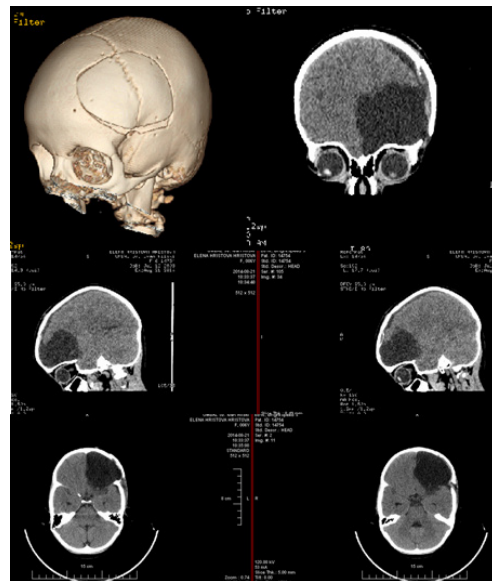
Postoperative CT after fronto-parietal craniotomy with visibly total tumor excision.
